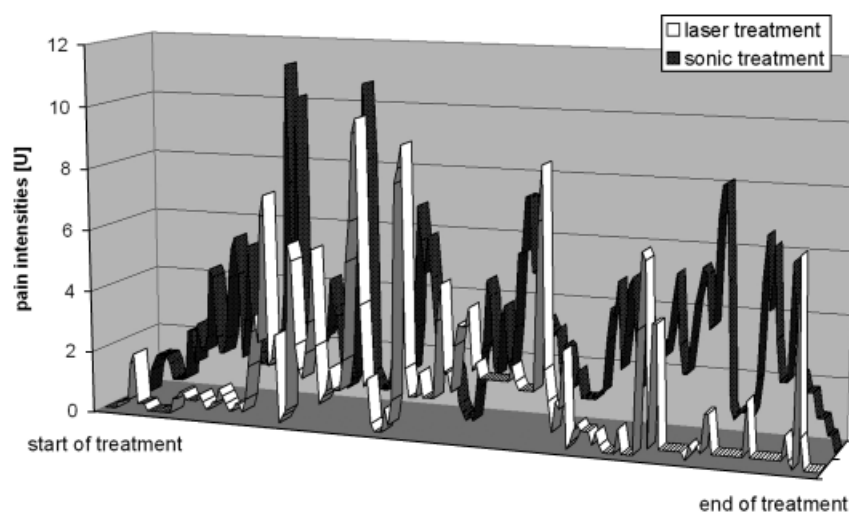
Pain scores during laser and sonic treatment. Pain values (U) show the mean values of inter-modal intensity comparisons for 11 patients under study. Pain peaks could be observed both in the laser and in the ultrasonic group, reaching comparable intensity levels.
